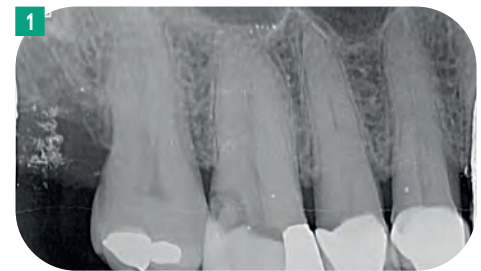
Preoperative radiograph (March 2022)
